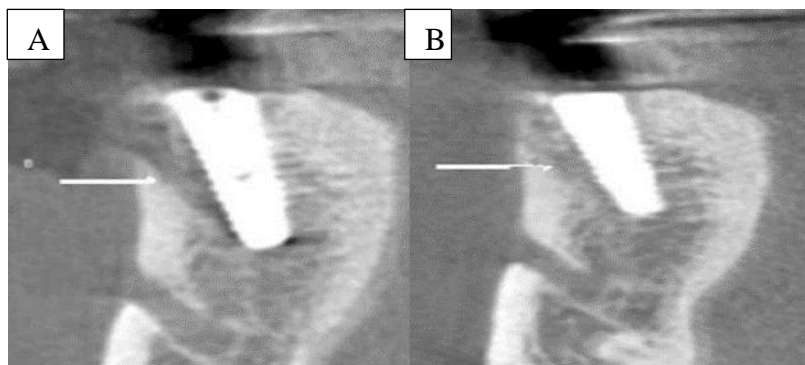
After 6 months, computed tomography (CT) scan around buccal wall defect (arrow) showed more radio-opacity than the initial implantation with auto-tooth bone grafting. A. Initial CT view. B. CT view after 6 months. (Um et al., 2020).
